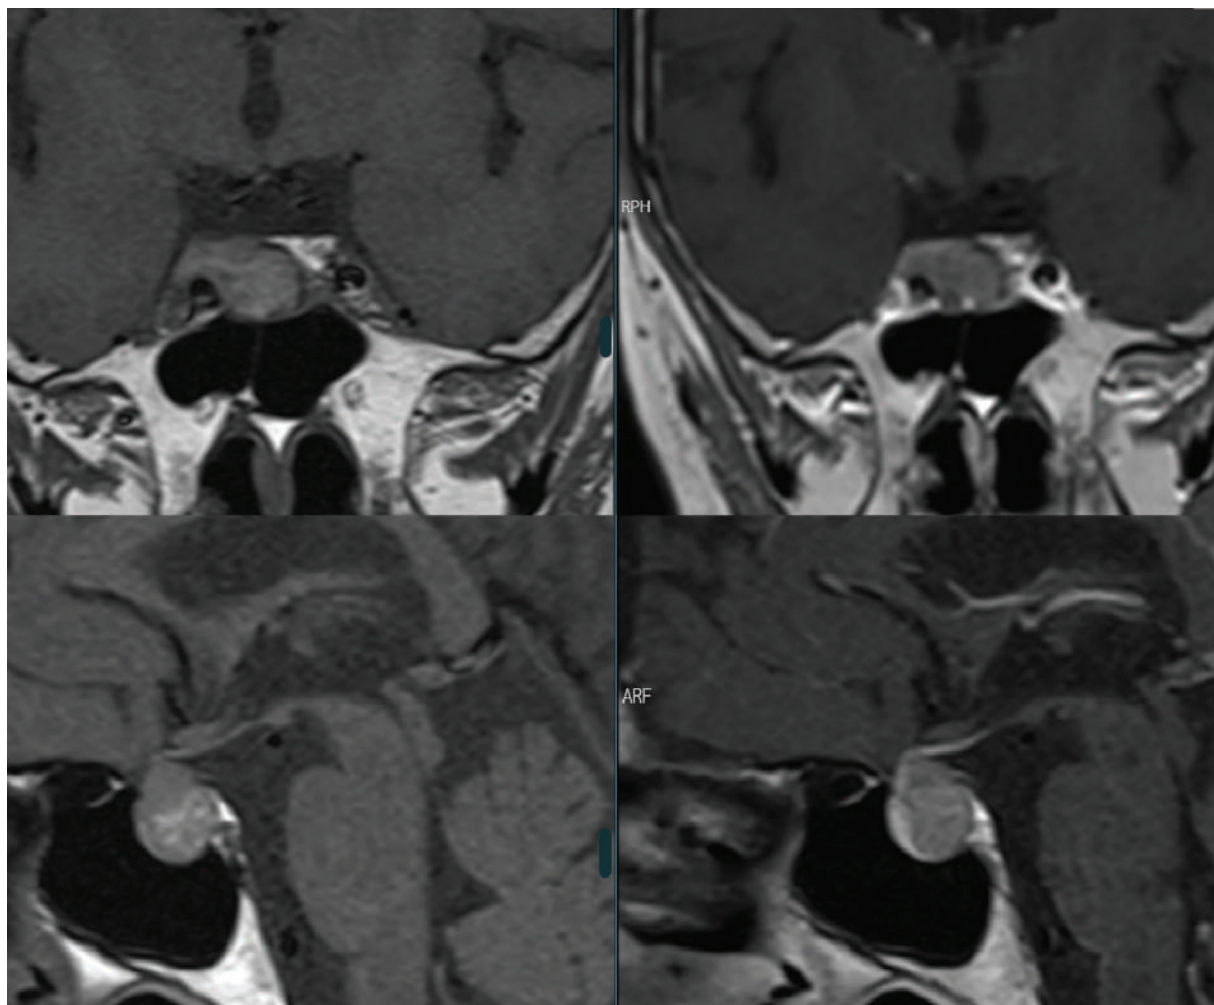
First MRI of the patient, in coronal (superior half) and sagittal (inferior half) sections, precontrast T1 weighted images on the left and T1 postcontrast on the right. A sellar mass is observed with parasellar extension on the right over the cavernous carotid artery and surpassing it, therefore being classified as Knosp 3A. It is a heterogeneous lesion, with sparse high intensity spots in T1 and less postcontrast enhancement than the pituitary parenchyma surrounding it.
